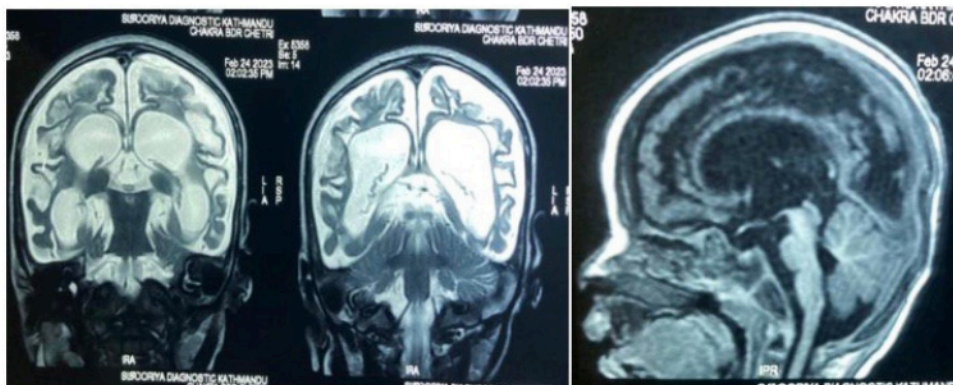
MRI brain showing encephalomalacia, dilated ventricles and poorly developed corpus
